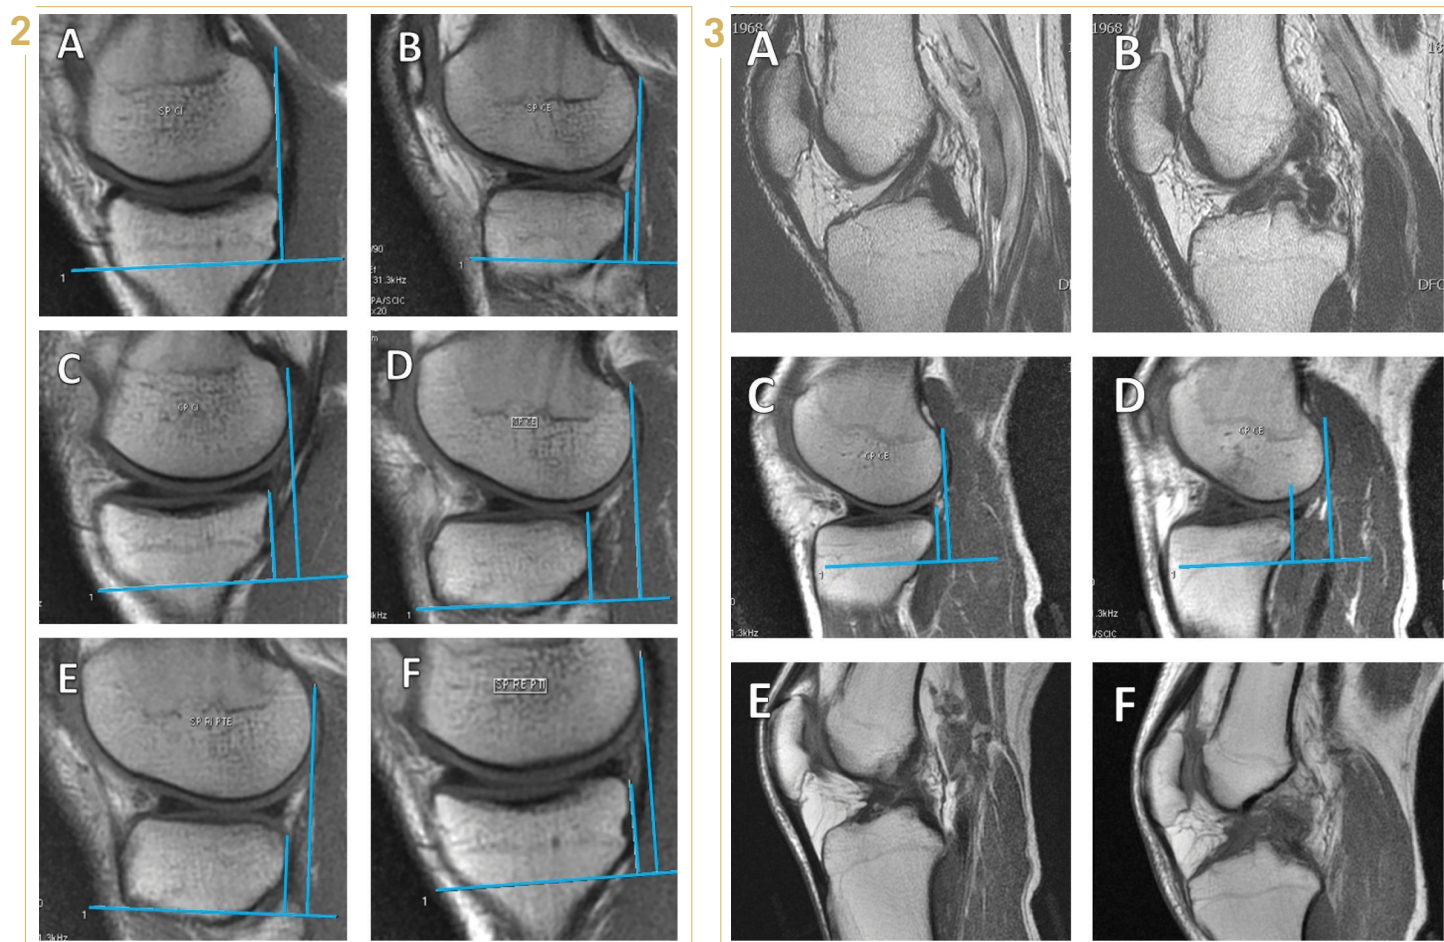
MRI measurements after PKTD examination for preoperative planning. (a) medial plateau, no stress (0 mm); (b) lateral plateau, no stress (3 mm); (c) medial plateau PA stress (7 mm); (d) lateral plateau PA stress (14 mm); (e) lateral plateau, maximum internal rotation (6 mm); (f) medial plateau, maximum external rotation (5 mm).
